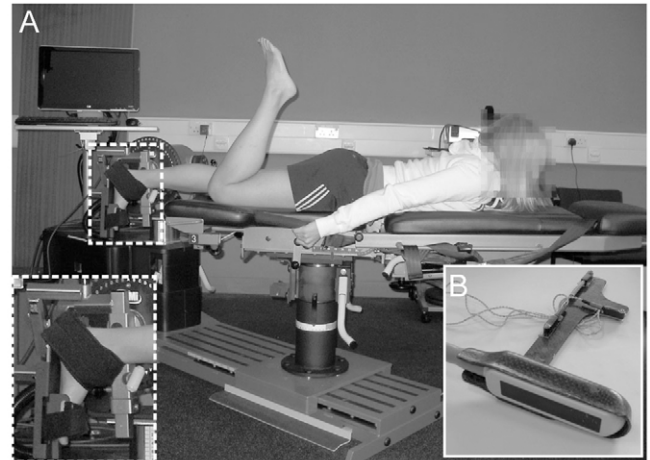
(A) The dynamometer setup. Participants lay in the prone position with the foot-plate at 90 deg to the shank. Strapping was applied over the dorsal aspect of the foot (inset). (B) The ultrasound transducer with a rigid carbon fibre attachment fitted. Three motion analysis markers were attached to track the position and orientation of the probe.
